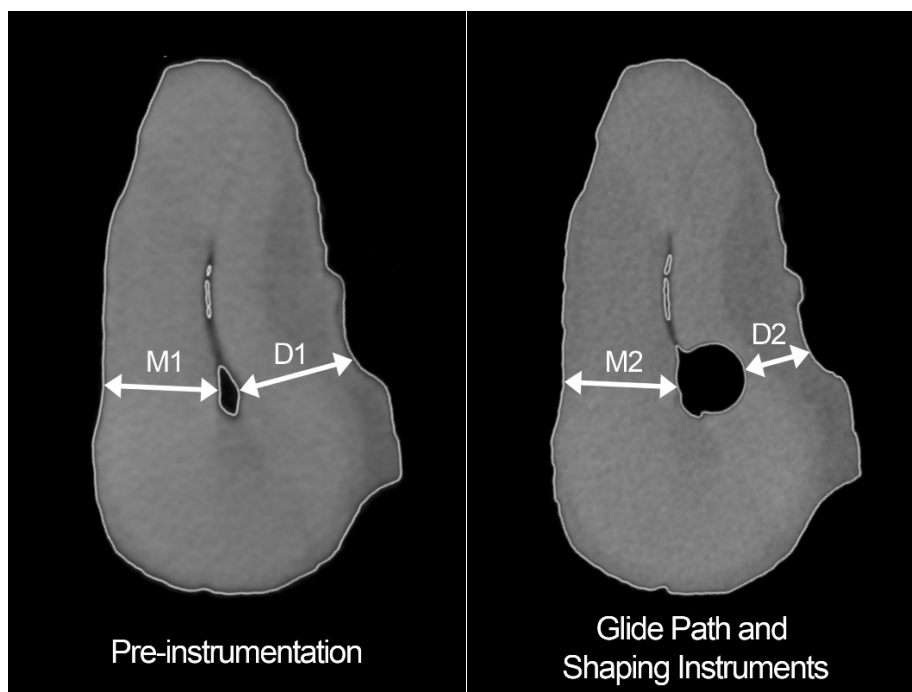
Pre-instrumentation- and post-canal-shaping CBCT images showing the effect of glide path preparation and points of measurements used for determination of canal preparation and points of measurements used for determination of canal transportation and centering ratio
